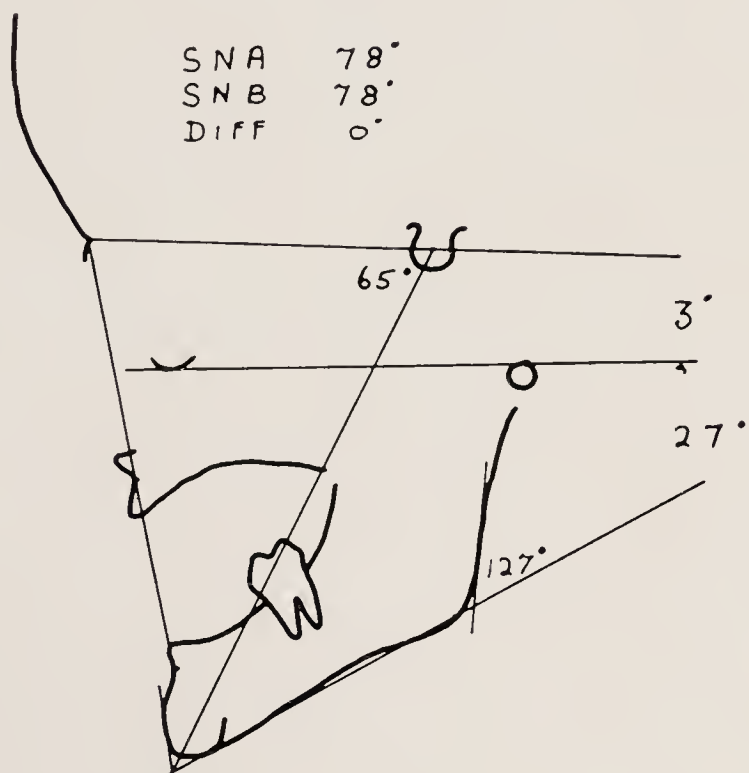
Tracing of lateral radiograph.
